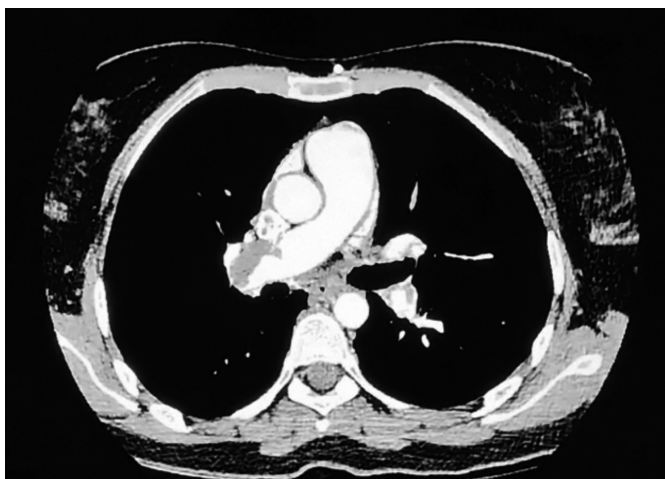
A CT pulmonary angiography showing occlusion of the first-order branch of the right superior pulmonary artery, first- and second-order branches of the right inferior pulmonary artery, and eccentric filling defect.
